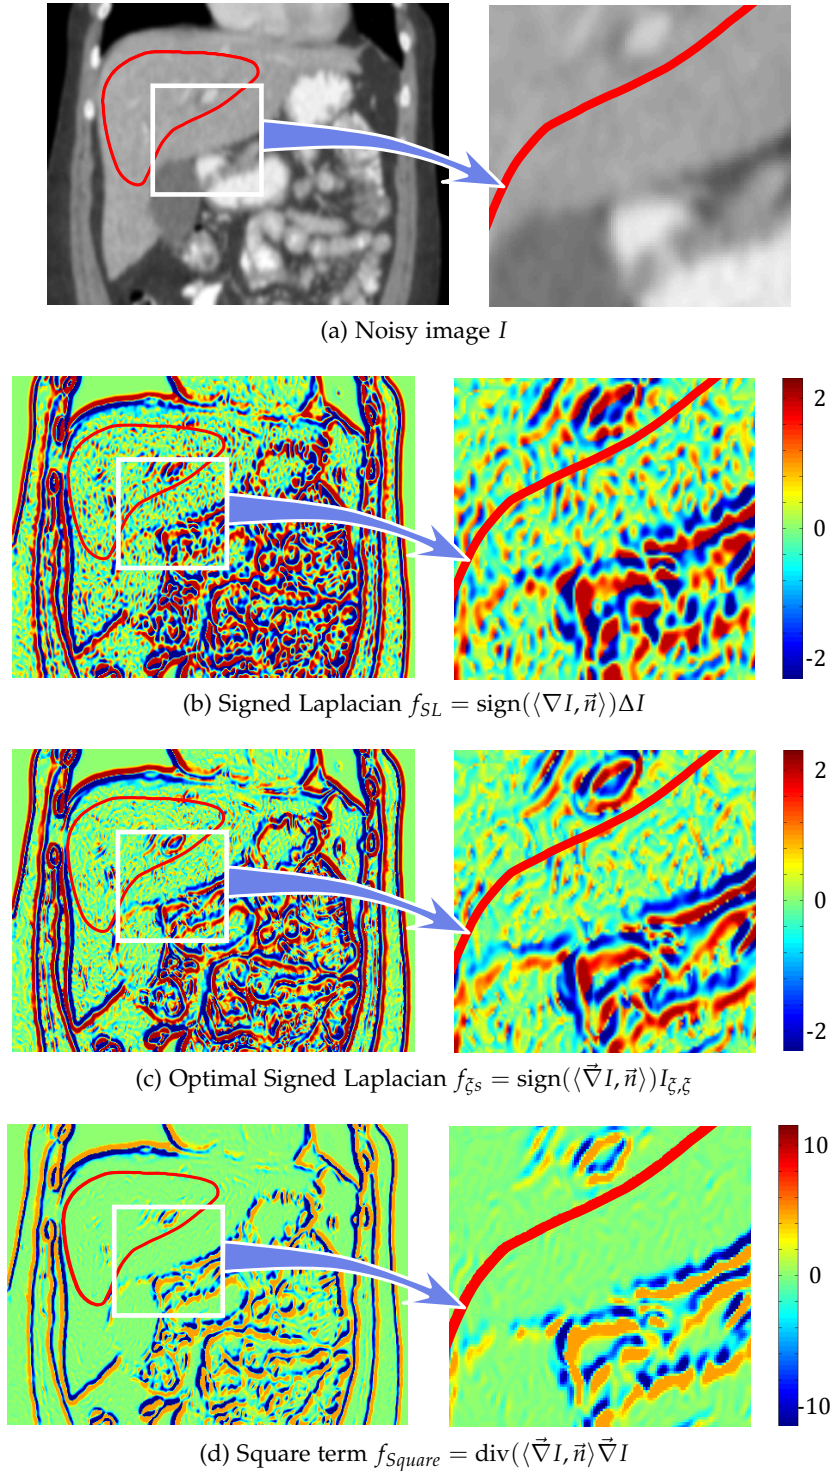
A 2D CT image (a) and the corresponding edge-based terms: signed Laplacian (b), signed optimal Laplacian (c) and square term (d), with the zero level of the implicit template (in red). Values are saturated for clearer visualization.
